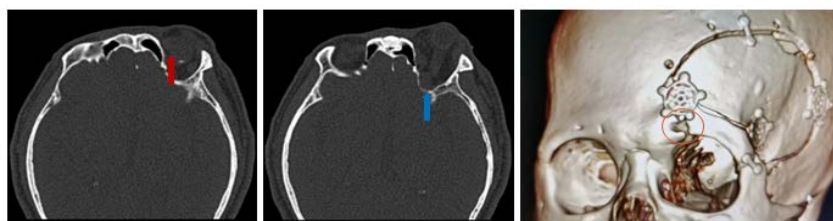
Orbital CT: Left superior rectus nodule with ophthalmic prominence (red arrow); left pterygoid body, pterygopalatine fossa, and cavernous sinus area with occupying lesions and bony changes (blue arrow); left supraorbital fissure enlarged (red circle), left supraocular vein tortuous
